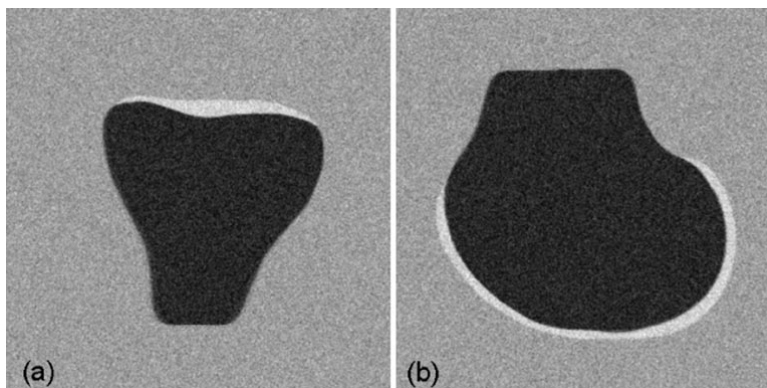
Kauffmann et al., 2003 [30]. Synthetic MR image of the knee based on a pool of 100 images. a) Tibial bone and cartilage. b) Femoral bone and cartilage
